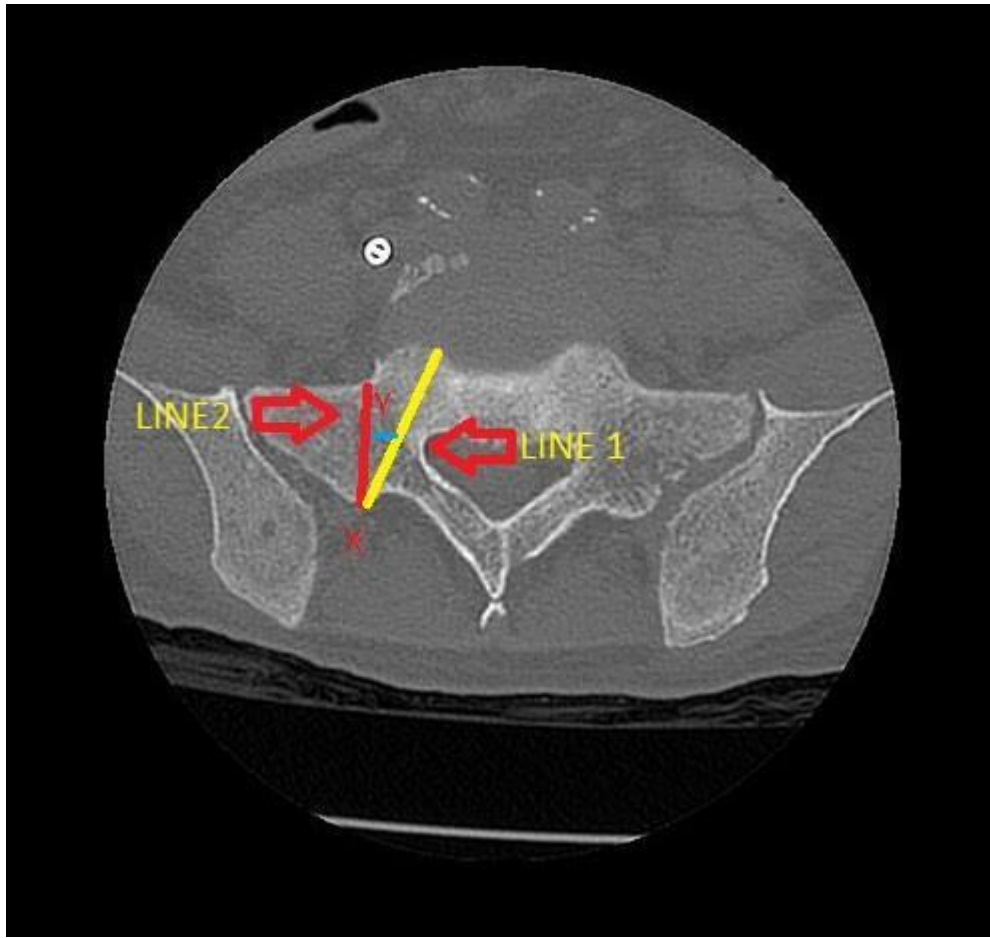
CT scan at S1 pedicle at desired entry point level ; X is proposed new entry point; Y is optimum angle for screw insertion; Line 1 : Screw length at optimum angle ; Line 2: Screw length at 0 degree trajectory.
